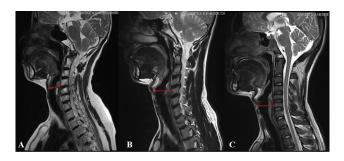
MRI films of neck showing the topography of vocal cords (marked as red line -) in relations to the cervical spine, 3A-vocal cords related to C4 level (8.2% cases), 3B-vocal cords related to C5 vertebra (89.1% cases) and 3C-vocal cords related to C6 (2.7%)
